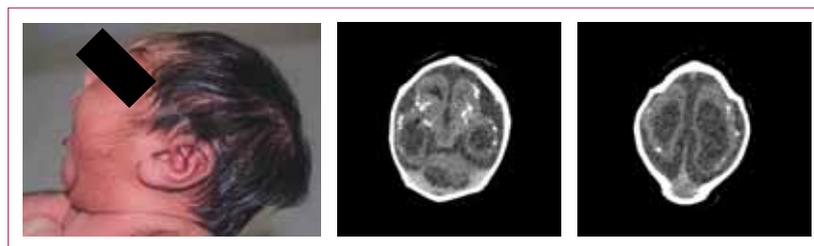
Newborn baby with microcephaly with laboratory-confirmed Zika virus and abnormalities detected on CT scan
